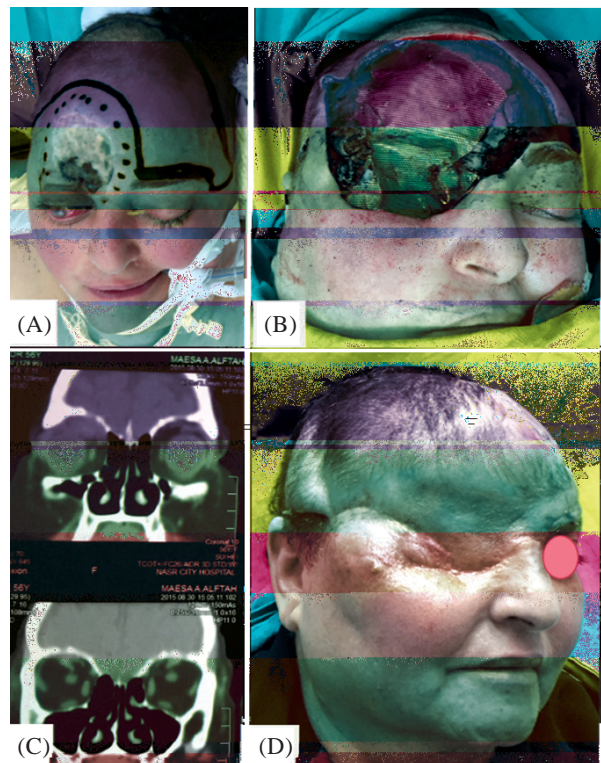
A: A 57 years old female patient with recurrent Basal cell carcinoma (BCC) involving the right aspect of the forehead with ocular muscles infiltration. B: Titanium mesh application for skeletal reconstruction after orbital exenteration and resection the orbital roof, medial wall, and adjacent bones. C: CT coronal cuts showing BCC intra-orbital extension. D: Seven months post-operative result.
